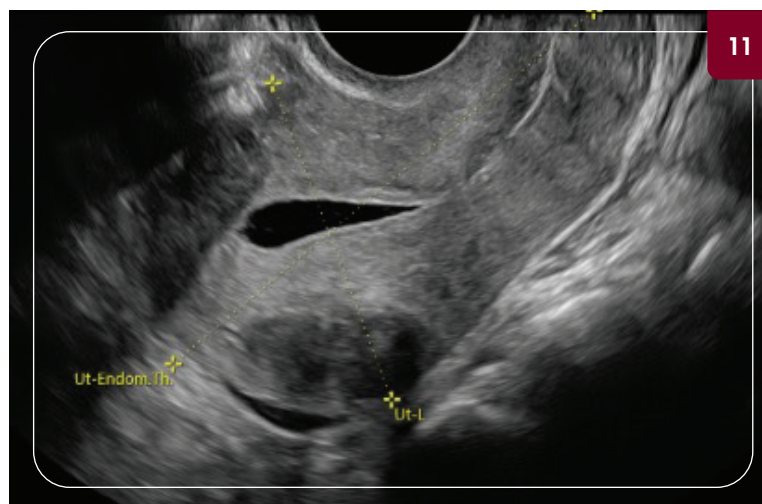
One-month post-operative mid-sagittal transvaginal saline ultrasound identifying the resected fibroid cavity to be well healed. The uterine cavity is now normal size and shape without intrauterine pathology.
